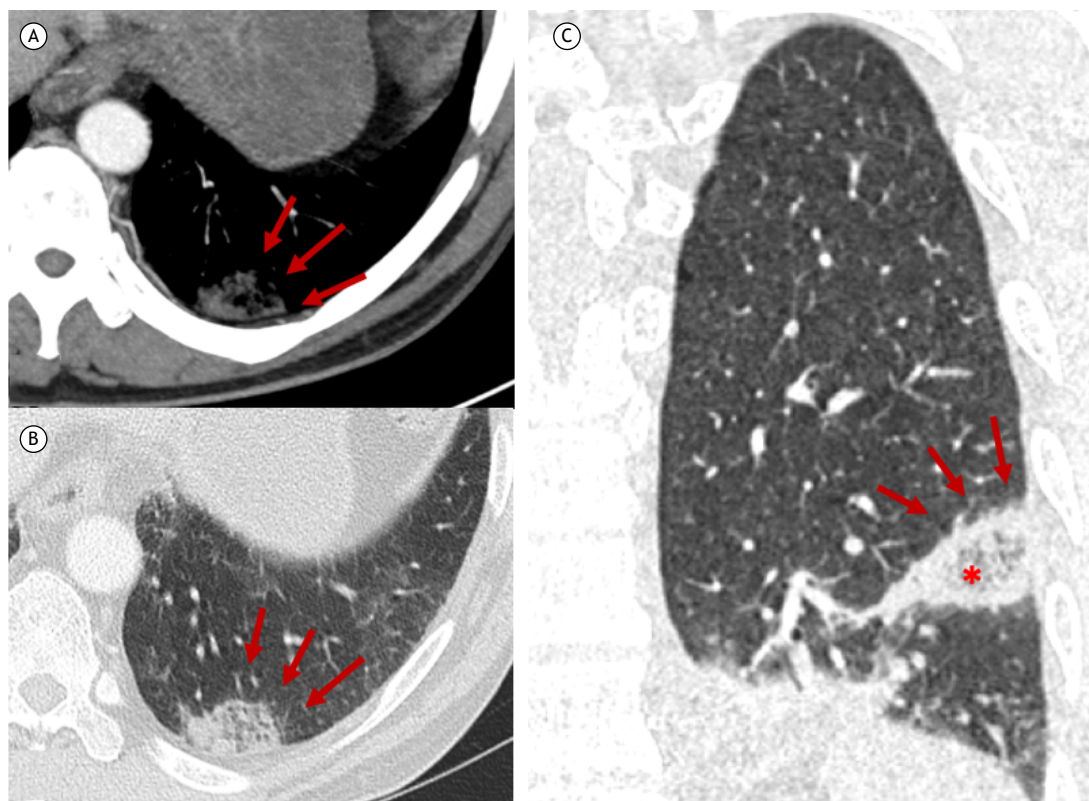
Axial (A) and coronal (B) CT scans with mediastinal window settings, and a coronal CT scan with lung window settings (C) showing the reversed halo sign, with ground-glass opacity surrounded by peripheral consolidation (arrows). Note the reticular pattern within the reversed halo sign, characteristic of peripheral pulmonary infarction (asterisk).
